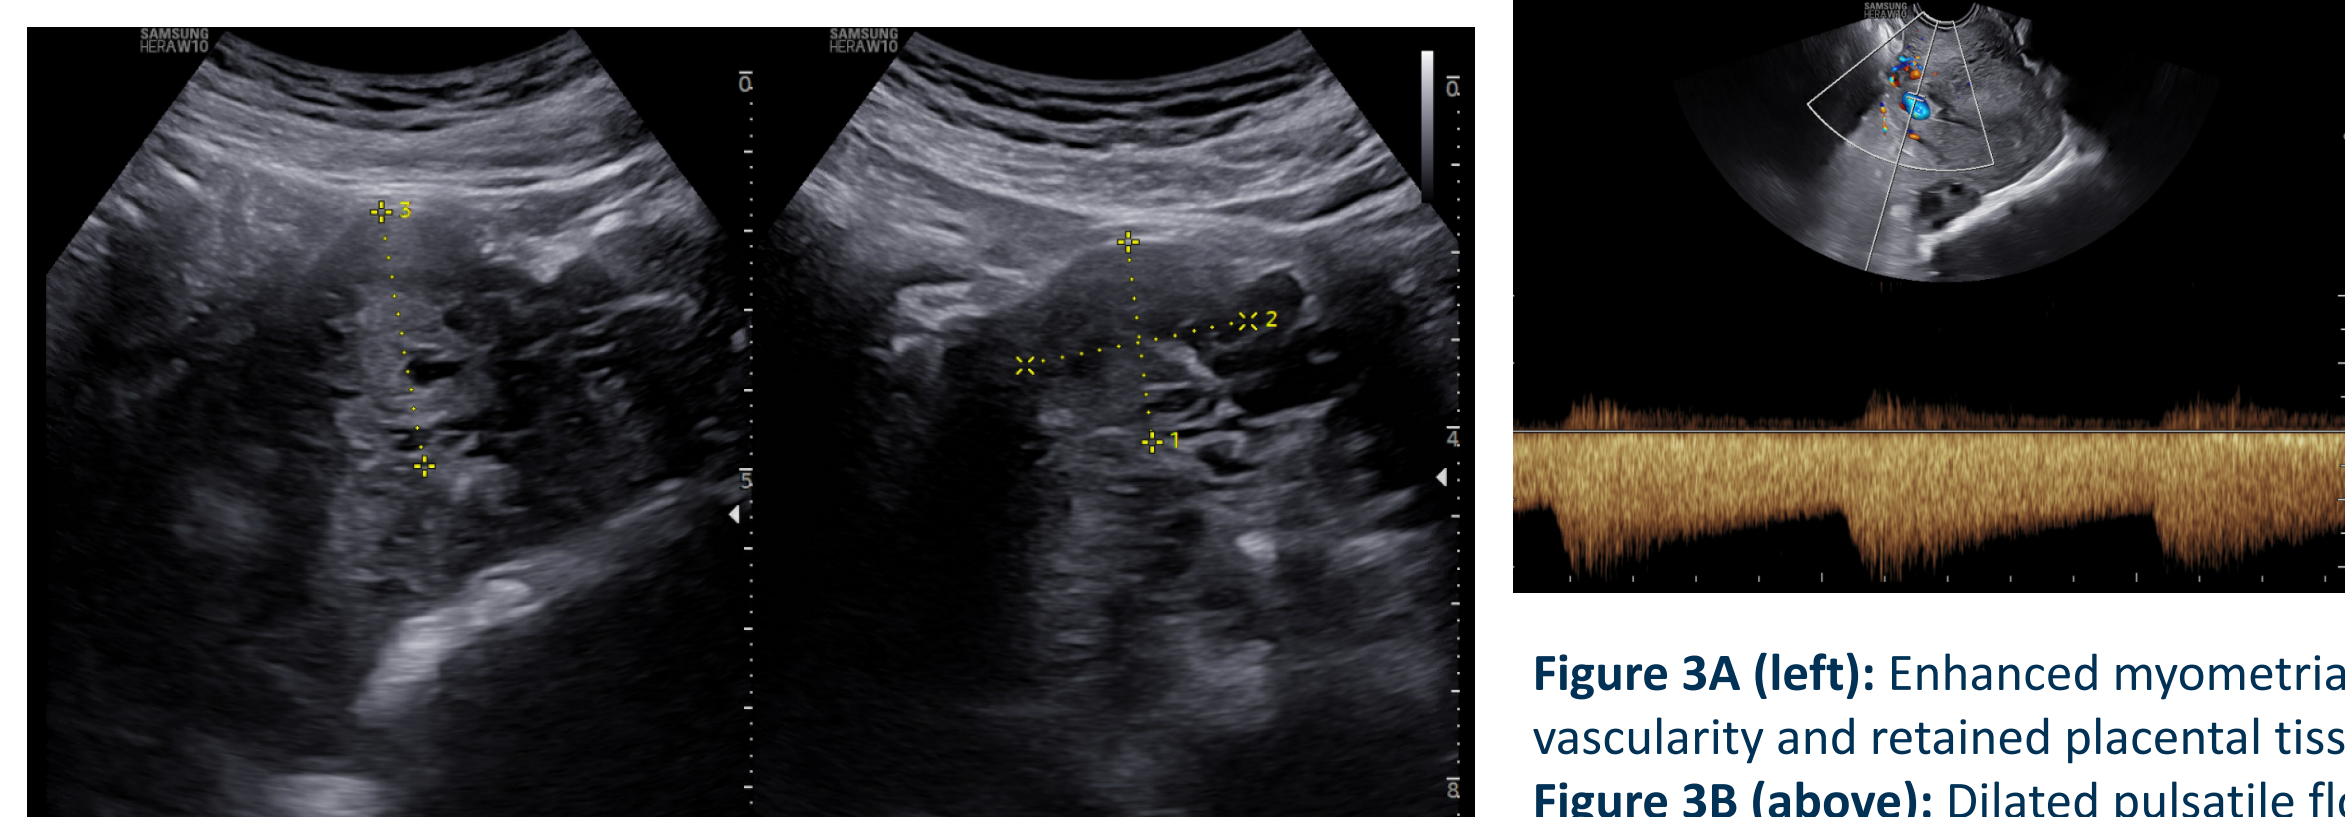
(left): Enhanced myometrial vascularity and retained placental tissue, Figure 3B (above): Dilated pulsatile flow within myometrium shown with spectral doppler
